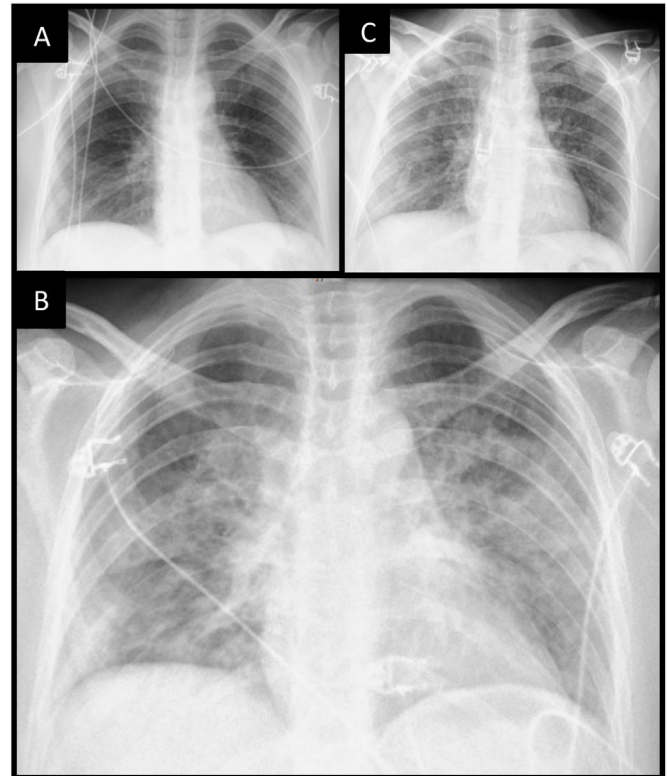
(A) Chest X-ray upon admission with normal characteristics. (B) Chest X-ray after admission to IUC at 24 h with alveolar pattern suggestive of acute lung edema. (C) Chest X-ray at 72 h with resolution of the acute lung edema pattern.
